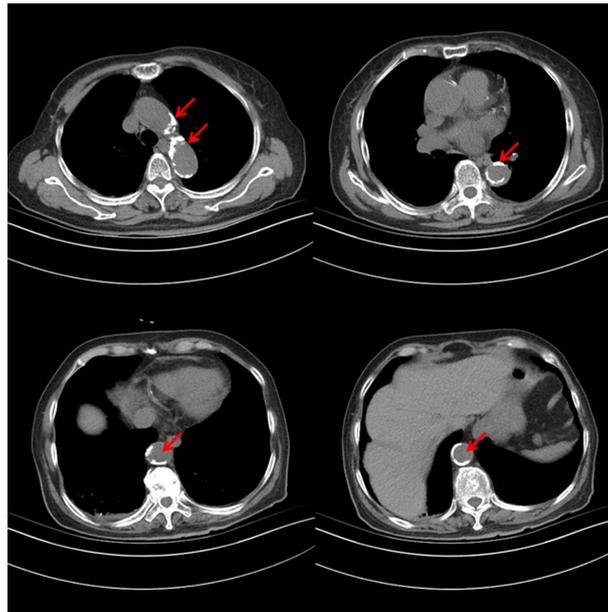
Multiple aortic atherosclerosis showed by chest CT.
